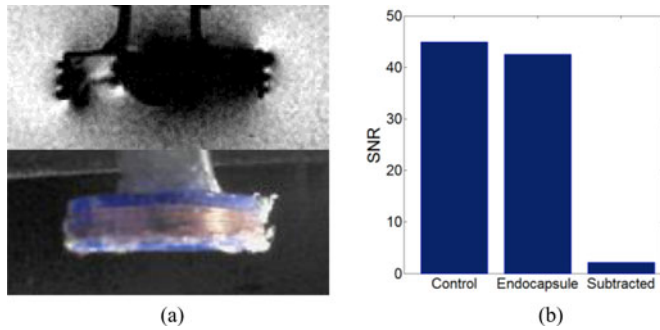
(a) Measurement of endocapsule MRI compatibility. (b) Evaluation of induced image artifact and signal SNR.
